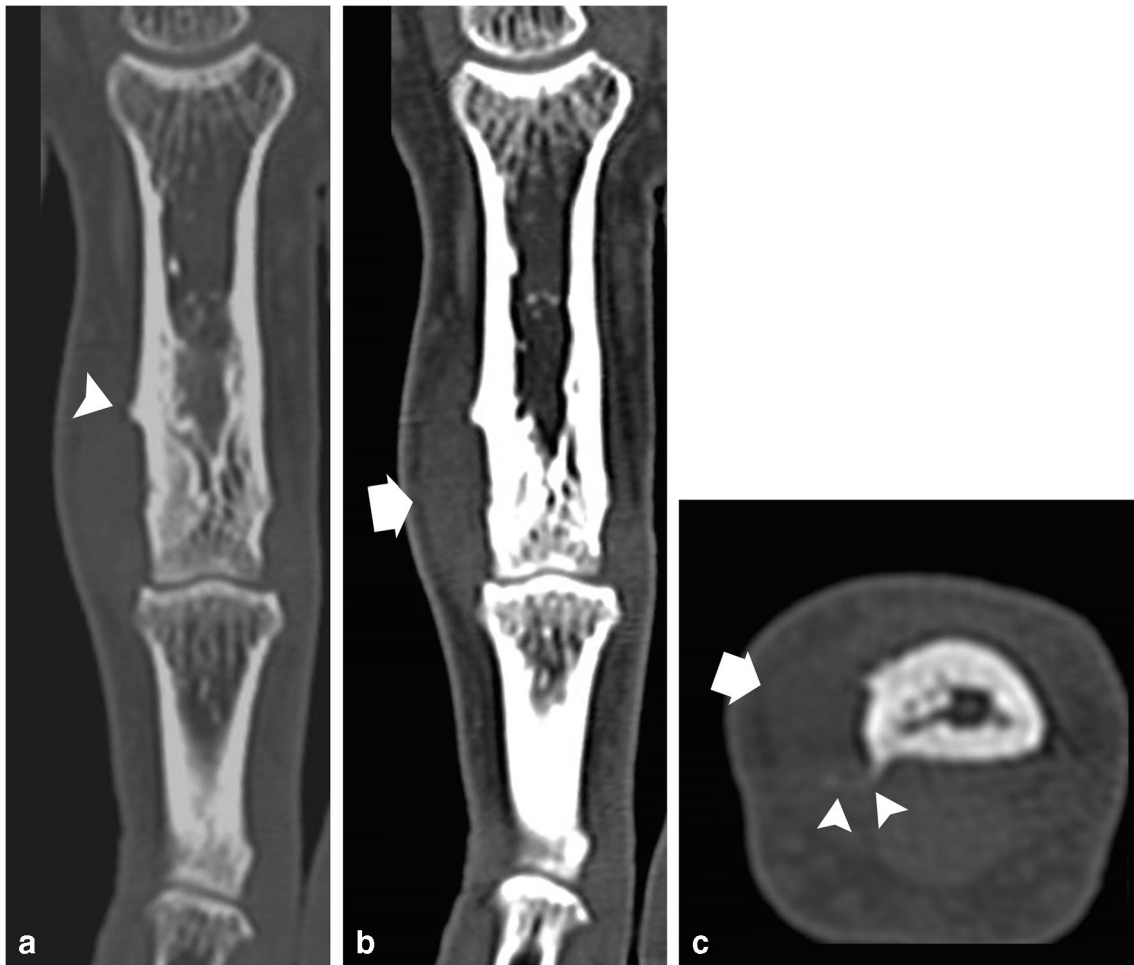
Frontal (a, b) and axial (c) CT reformatted images demonstrating a small soft tissue tumor at the ulnar aspect of the head of the proximal phalanx (thick arrows) and subtle cortical buttressing from a chronic periosteal reaction at the proximal and dorsal aspects of the lesion (arrowheads)
